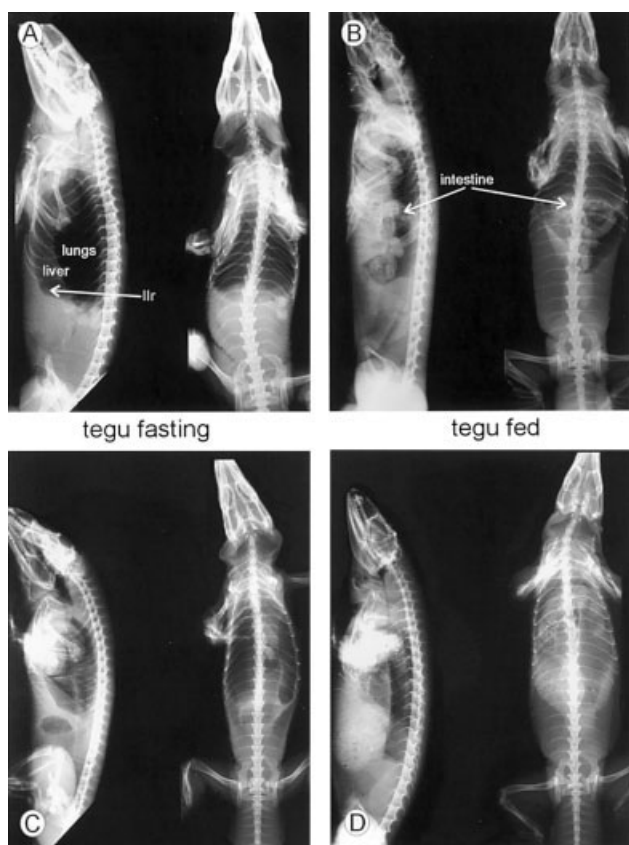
X-ray images of *Tupinambis merianae* with PHS (A,B) and without PHS (C,D). The left part of each picture shows an image in lateral–right direction and the right part in dorsoventral direction. The tegus on the left side fasted for 4 days and the ones on the right were fed the evening before the experiment. Note the clear pleurohepatic cavity in the tegus with intact PHS and the reduced lung volume in the tegus without PHS. llr, last long rib.
